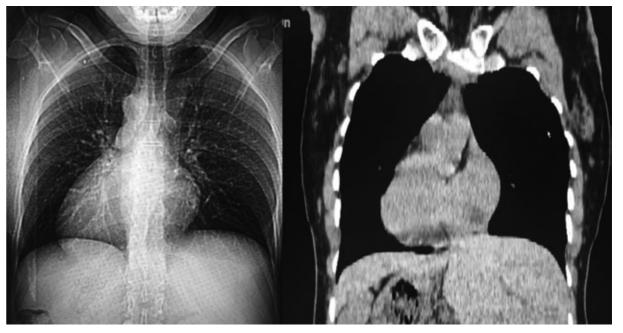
Axial CT scan slice of situs inversus with right-sided heart.
